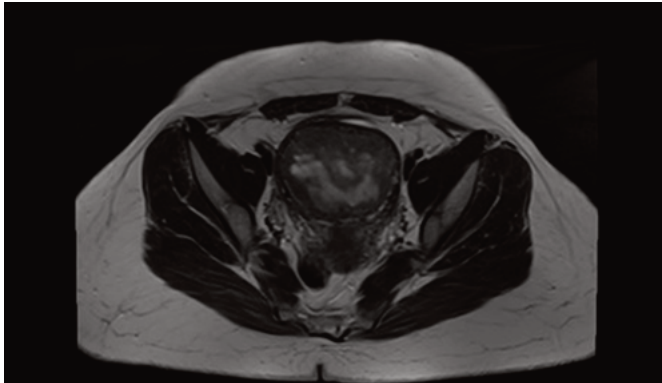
Preoperative pelvic MRI of Case 9. (A) Coronal T2-weighted image demonstrates a large pelvic mass compressing the bladder, with the uterus not clearly visualized. (B) Sagittal T2-weighted image shows the lesion arising from the anterior uterine wall, consistent with a FIGO type 4-6 intramural leiomyoma, without distortion of the endometrial cavity. (C) An axial T2-weighted image delineates the tumor margins and confirms its intramural localization, with mass effect on the uterine contour.
